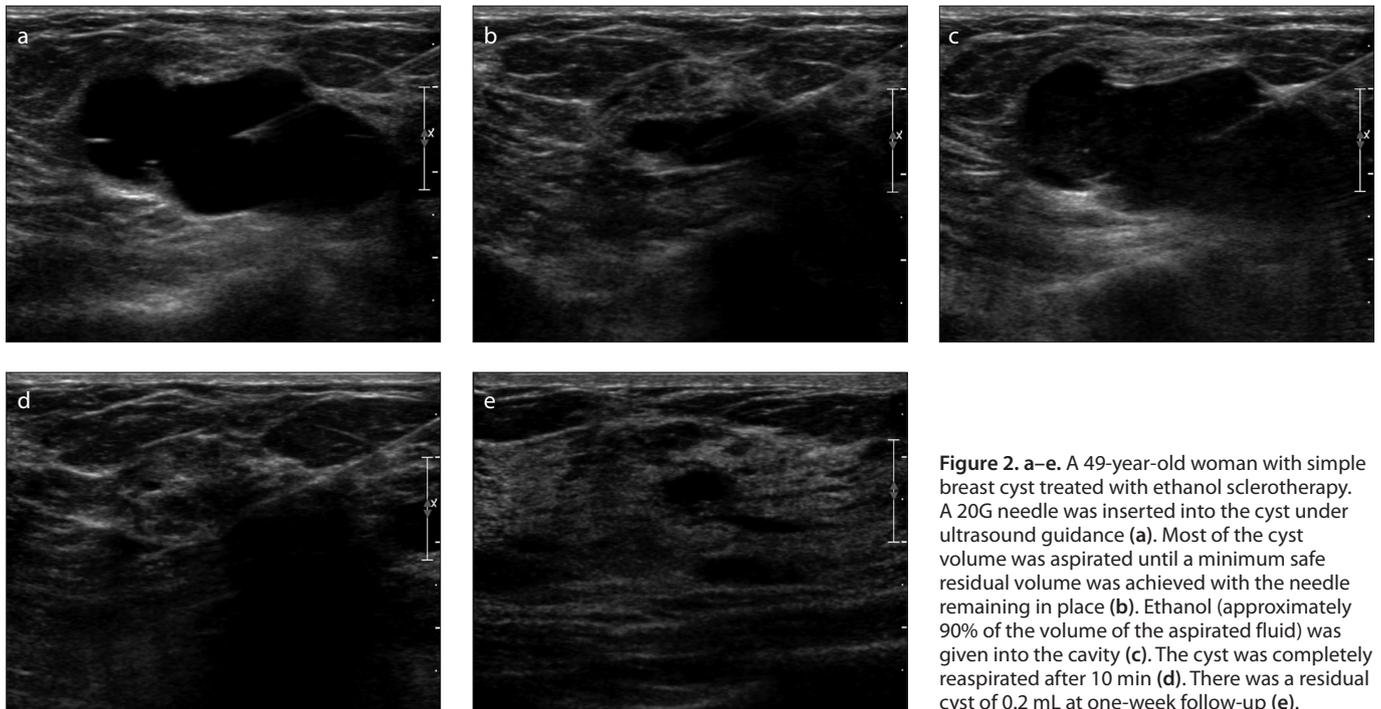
a–e. A 49-year-old woman with simple breast cyst treated with ethanol sclerotherapy. A 20G needle was inserted into the cyst under ultrasound guidance (a). Most of the cyst volume was aspirated until a minimum safe residual volume was achieved with the needle remaining in place (b). Ethanol (approximately 90% of the volume of the aspirated fluid) was given into the cavity (c). The cyst was completely reaspirated after 10 min (d). There was a residual cyst of 0.2 mL at one-week follow-up (e).
